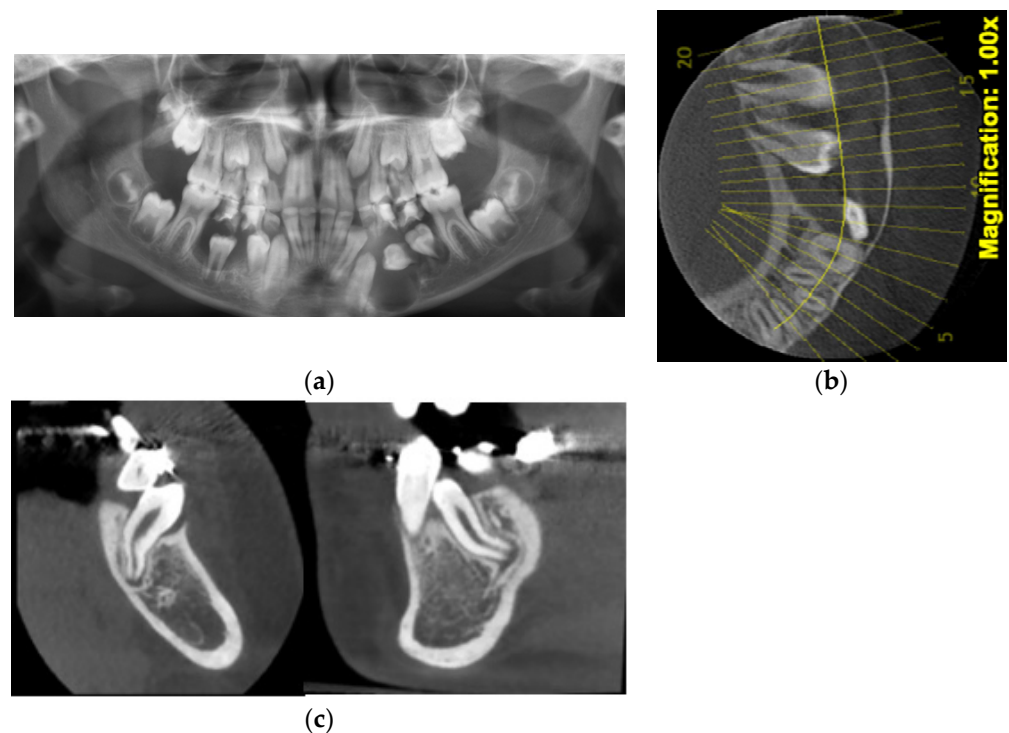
(a) Initial panoramic X-ray revealed large DCs on both sides of the mandible. (b) CBCT image showing the labiolingual orientation of the lower left first and second premolars. (c) CBCT showing root DL of the left first premolar.
